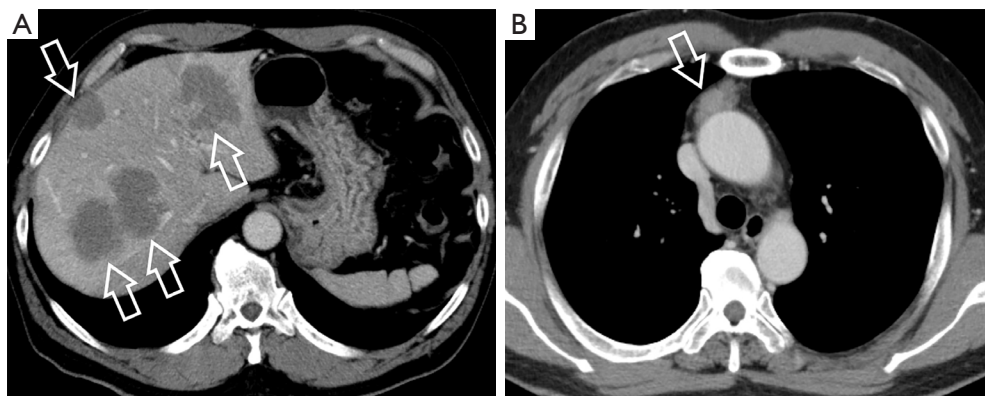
Case 2: a male patient in his fifties, without any noteworthy medical history, was diagnosed with numerous liver neoplasms during a regular health check-up abdominal ultrasound. (A) Contrast-enhanced CT (axial), the liver level; (B) contrast-enhanced CT (axial), the mediastinal level. A CT scan with contrast revealed multiple ill-defined low-density lesions in the liver (A, arrows) and a nodule in the anterior mediastinum (B, arrow). CT, computed tomography.
